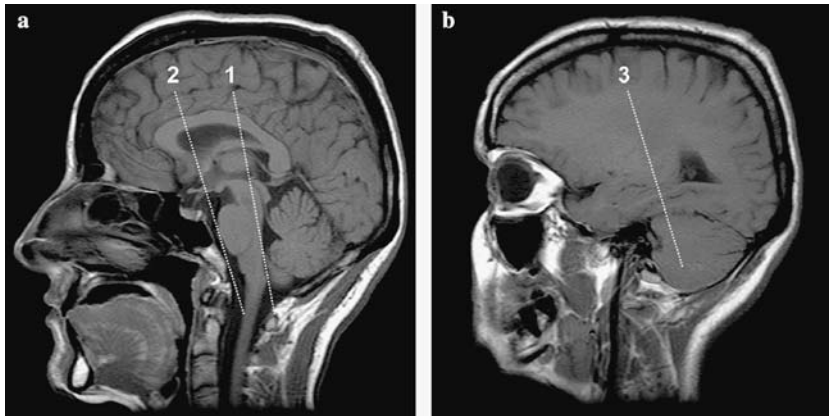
Sagittal MR images demonstrate the location of three of the four lines tested. (a) mid-sagittal level showing the posterior commissure-obex line [1] and the line tangential to the anterior surface of the pons [2] (b) para-sagittal image showing the line orthogonal to the long axis of the right hippocampus [3]. The fourth line was orthogonally placed on the opposite hippocampus
